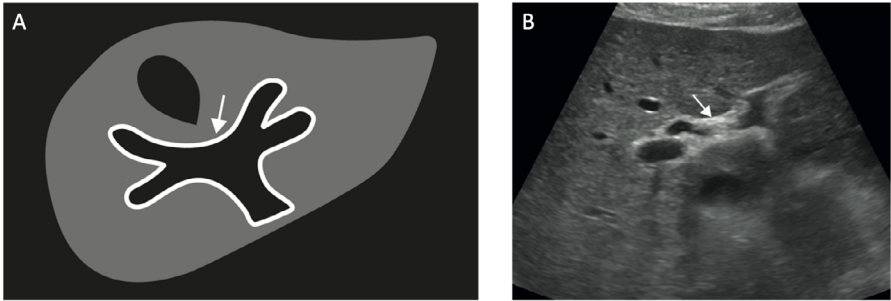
Periportal thickening in a patient with severe COVID-19. (A) Representation of a liver with periportal thickening on ultrasound (white arrow). (B) Ultrasound study demonstrating periportal thickening (white arrow).
